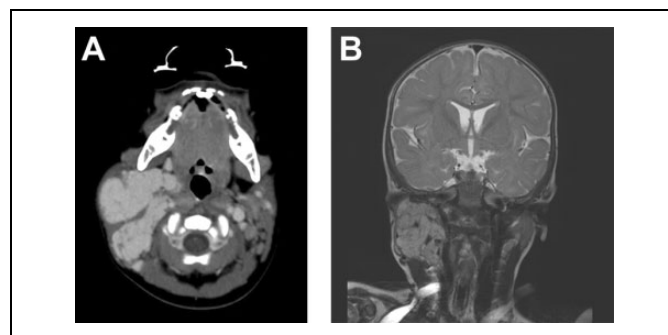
2012 Axial CT scan with contrast (A) and coronal T2 MR image (B) showing a cervicofacial hemangioma on the right. CT indicates computed tomography; MR, magnetic resonance.
